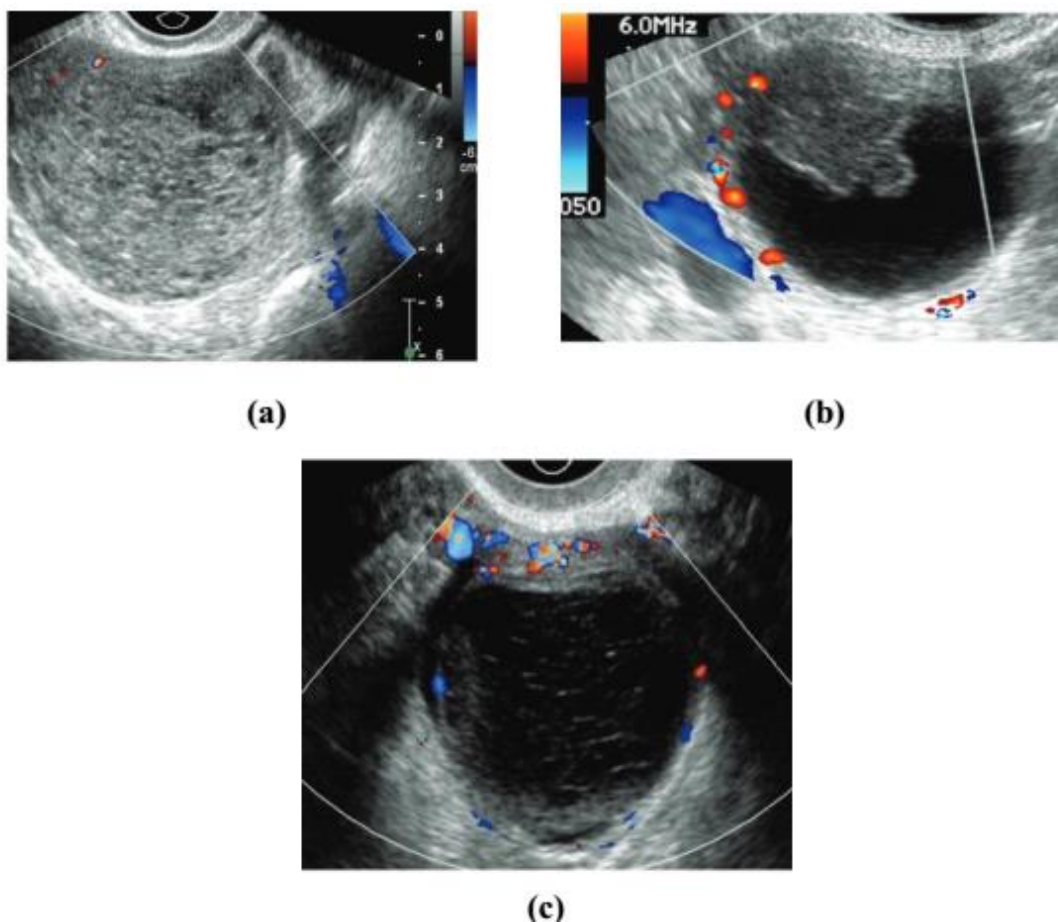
HOC cysts: (a) Coronal transvaginal color Doppler US image of the ovary demonstrates echogenic, avascular, heterogeneous non shadowing material compatible with acute blood clot. (b) Coronal transvaginal color Doppler US image of the right ovary in a different patient demonstrates a cyst with a solid- appearing mural nodule. The nodule is avascular with concave edges, findings that are characteristic of a retracting clot. (c) Sagittal trans-vaginal color Doppler US image of the left ovary in a third patient demonstrates a cystic structure with avascular irregular fine linear echoes that represent fibrin strands in a resolving hemorrhagic cyst (6).
